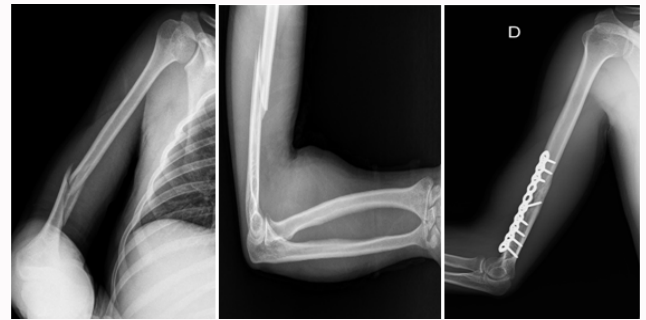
X-ray of the elbow and arm showed a spiral fracture of the distal third of the humerus.
